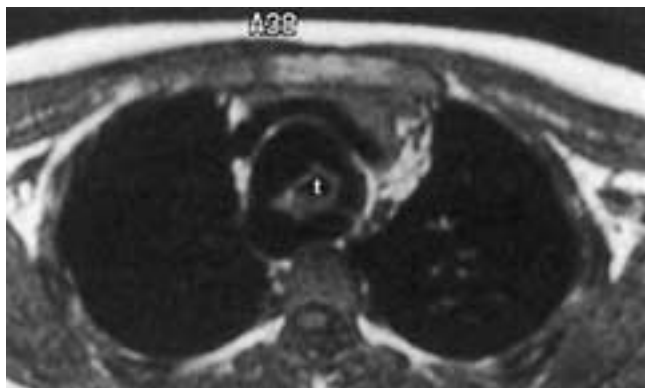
Double aortic arch causing tracheal compression in a 10-year-old child with chronic airway obstruction. T1-weighted axial image obtained with respiratory compensation shows a double aortic arch encircling the trachea (*t*).
